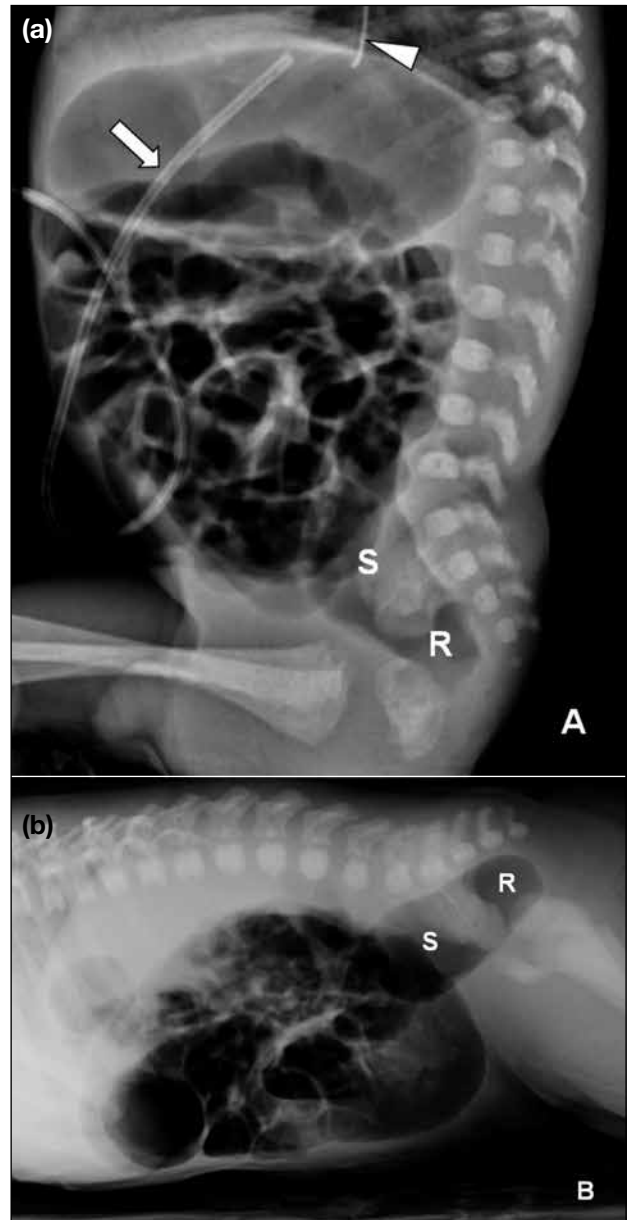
(a) Lateral abdominal radiograph of a 4-day old neonate, and (b) cross-table prone lateral view of a 14-day old infant; both show a reversed rectosigmoid index (<1) where the rectum (R) is narrower than the sigmoid (S) colon. Also seen in (a) are an umbilical venous catheter (arrow) and the tip of an orogastric tube (arrowhead).
